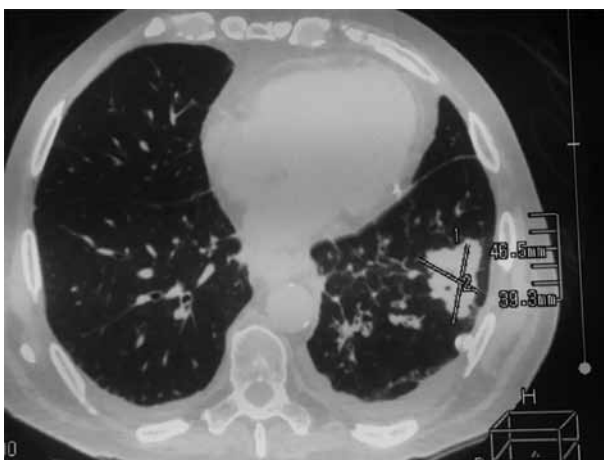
CT scan of the thorax showing tumor in the left lung.
